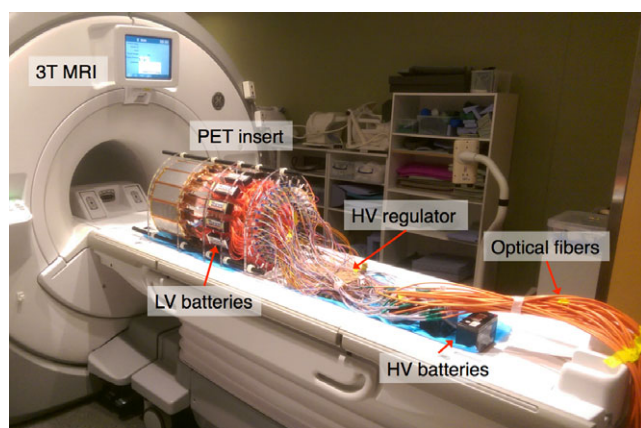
PET insert on 3T MRI bed, powered with batteries and connected to the data acquisition system with 20 m length optical fibers. The data acquisition system resided in the adjacent control room. [Color figure can be viewed at wileyonlinelibrary.com]
